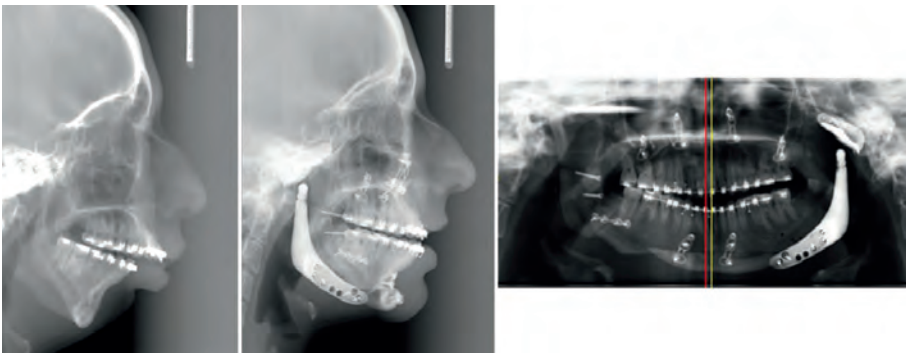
Case #1 continued. (a) Preoperative profile cephalogram. (b) Postoperative profile cephalogram. (c) Orthopantomogram. The red line indicates the upper dental midline, and the yellow line indicates the lower dental midline
